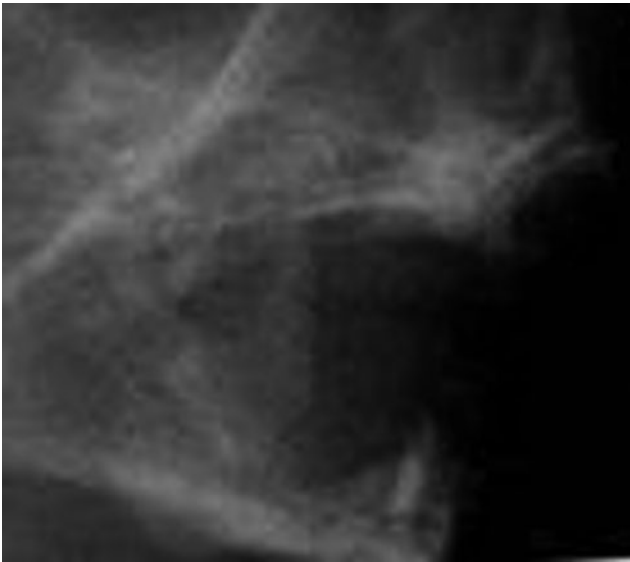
Radiograph of upper and lower jaws of a fetus at the sixteenth week of intrauterine life showing the initial mineralization of deciduous incisors
